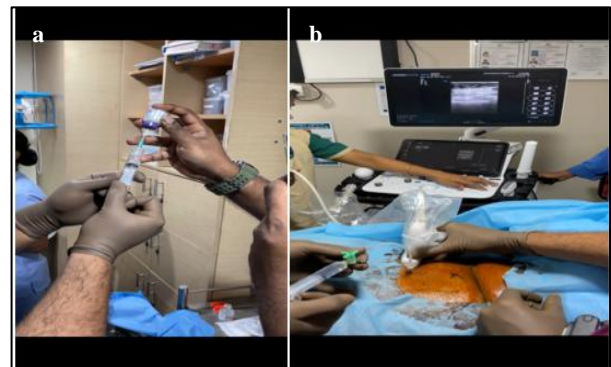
(a and b): Preparation and injection of BOTOX under ultrasound guidance done at our centre.
